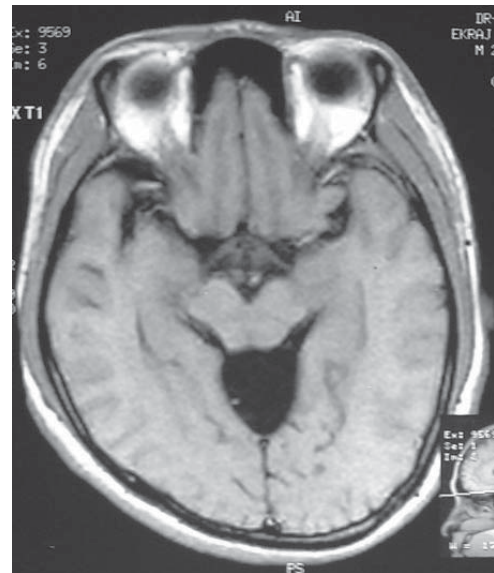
MRI in T1 sagittal section showing a large trigeminal cistern arachnoid cyst at the supratentorial location with compression of the brainstem and the cerebellum.
